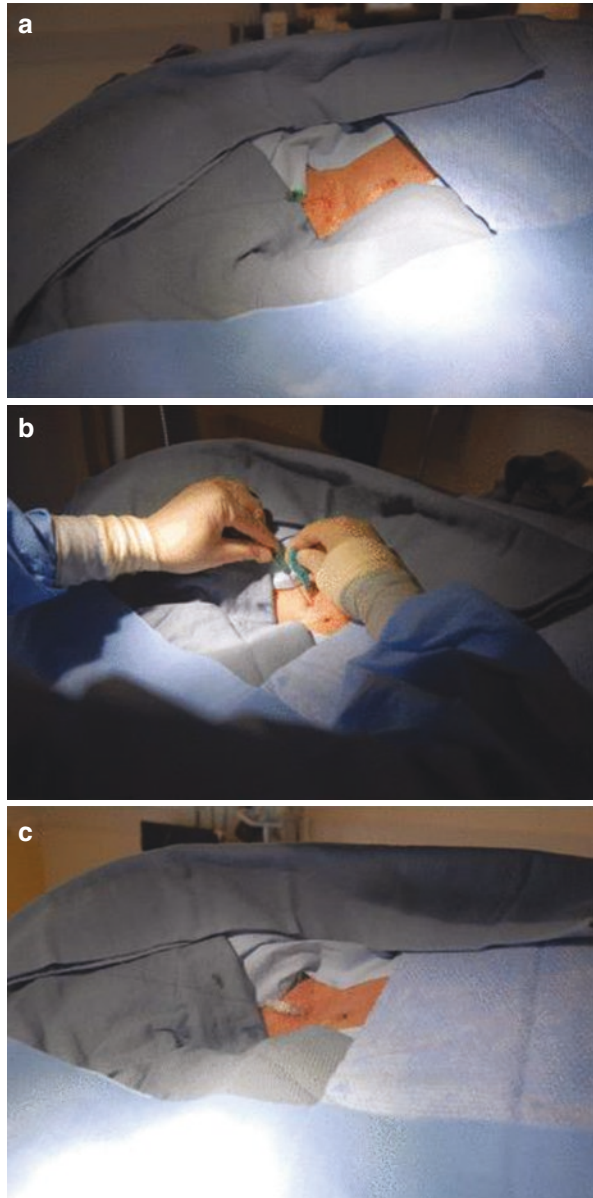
(a) Clean and drape the operative site. (b) Infiltrate the insertion site with lidocaine. (c) Puncture the vein with a micropuncture needle under ultrasound guidance
